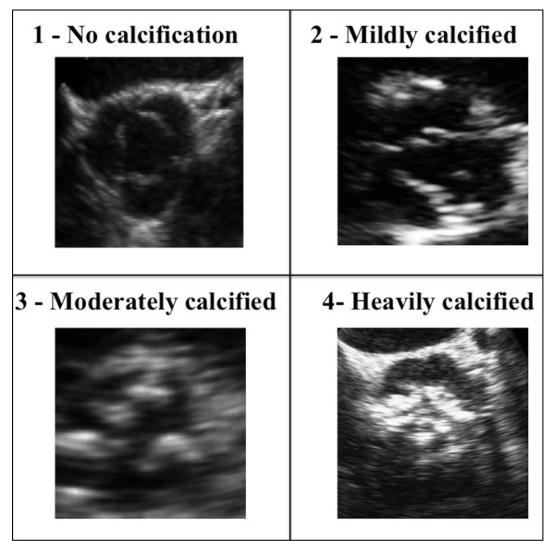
Evaluation of the degree of aortic valve calcification by echocardiography
